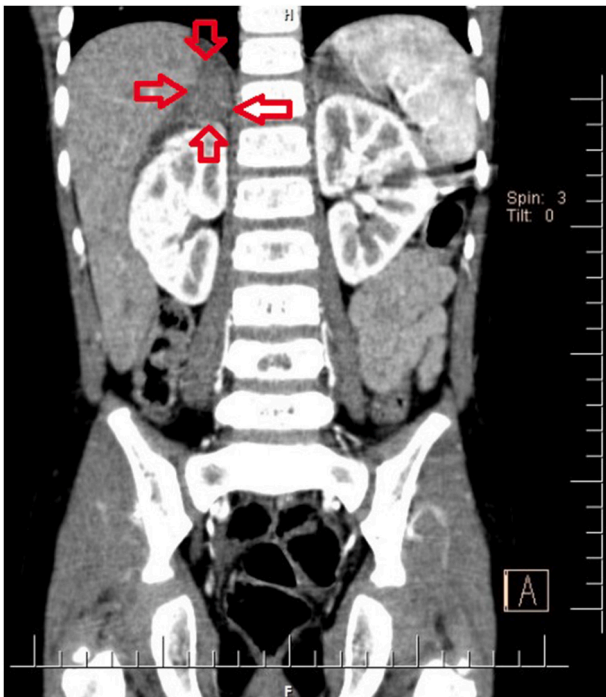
Coronal view of abdominal CT scan.
